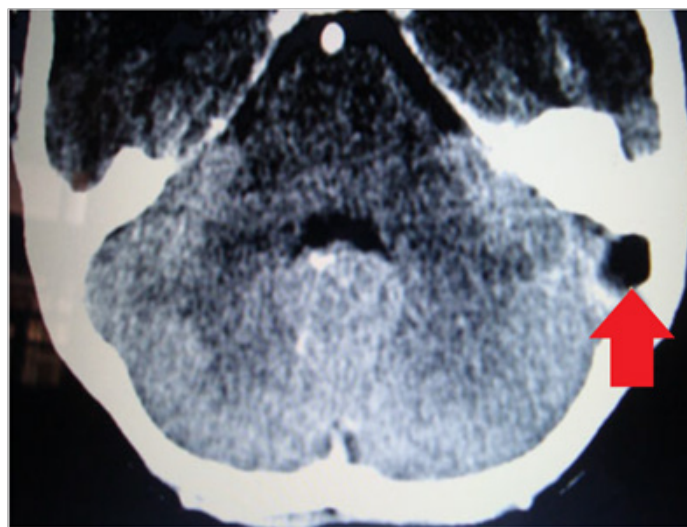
CT with contrast showing (arrow) absence of enhancement in the thrombosed left lateral sinus and enhancement of the dura surrounding the sinus (delta sign).
